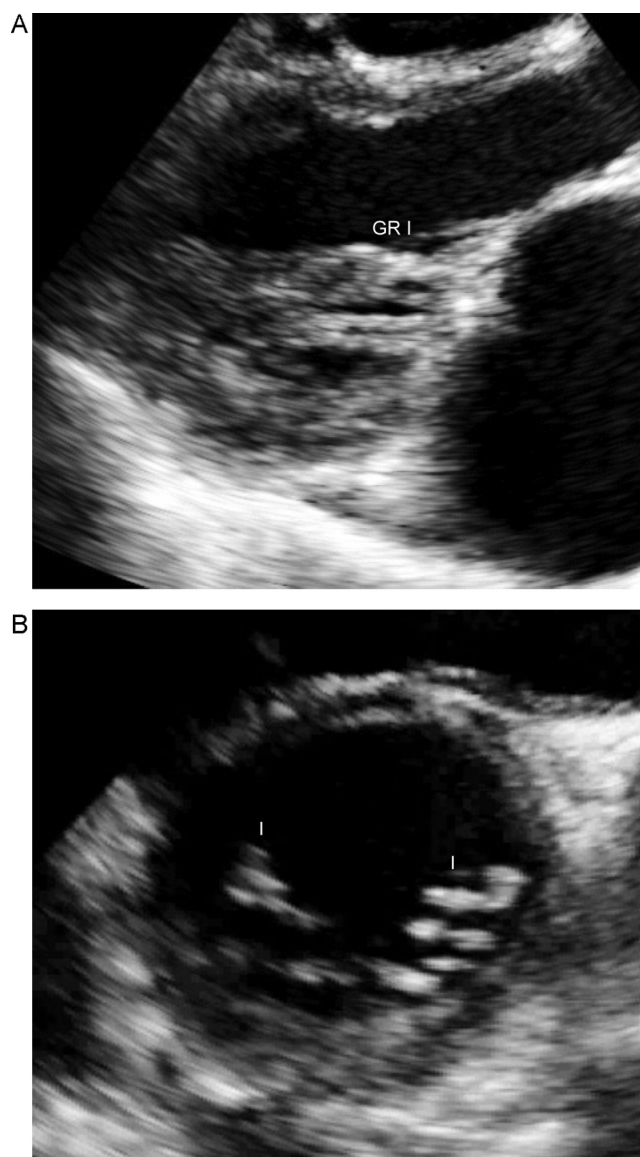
Parasternal long-axis (PLAX) (A) and short-axis (SAX) (B) view showing mild SVA pathology (Gr I).
